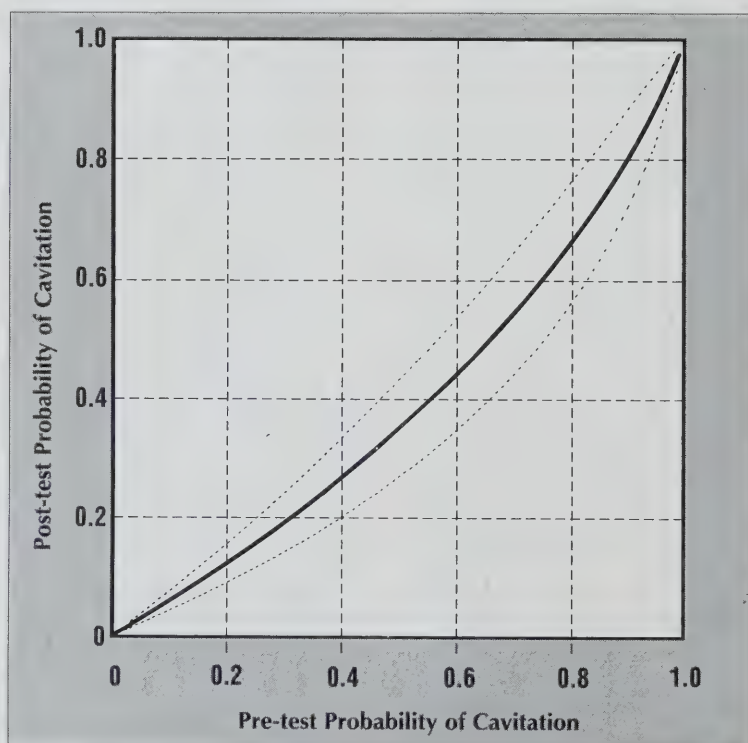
Pre-test and mean post-test probability of cavitation (± 95 per cent confidence interval) based on a negative radiographic test result.
